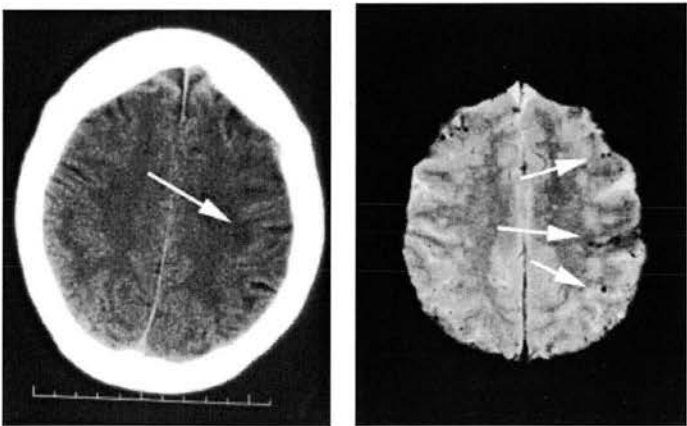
72 year old man with ataxia and loss of balance to right, no residual abnormality. Scanned at 20 days. CT on left, gradient echo right.
